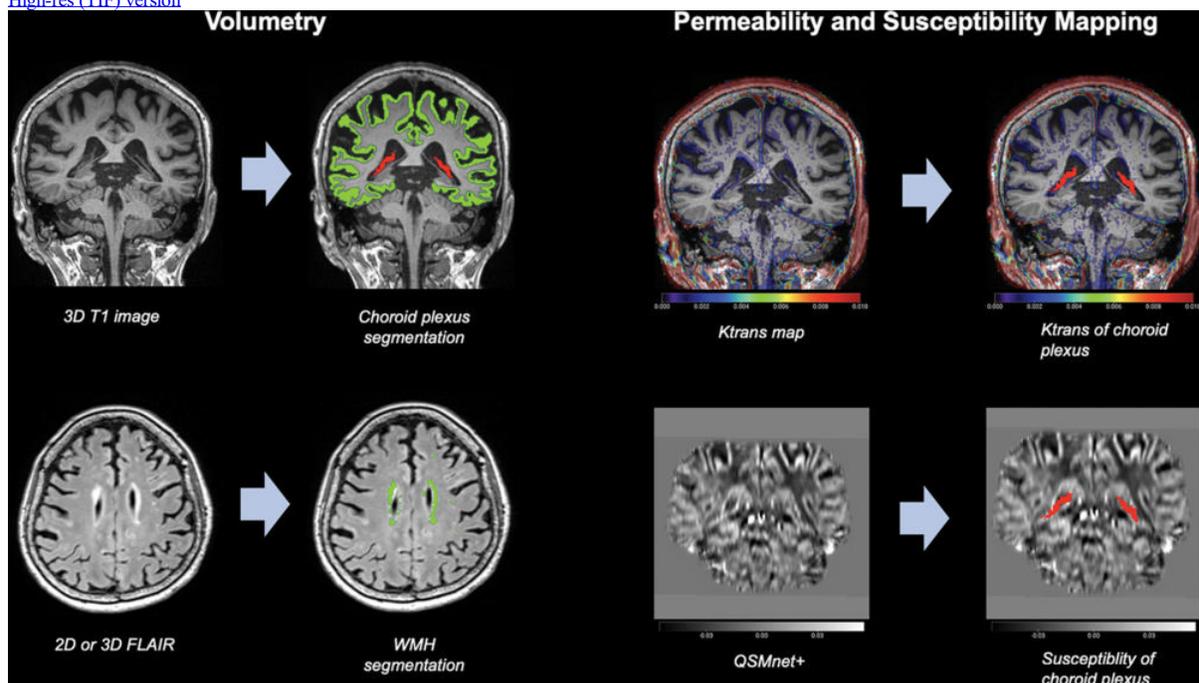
MRI processing steps. For volumetry (left), choroid plexus (CP) volume (red) and cerebral cortex volume (green) are segmented from T1-weighted volumetric images by using an automatic volumetric software (Inbrain) based on the FreeSurfer 6.0 platform (upper row). White matter hyperintensity (WMH) volumes (green) are also segmented from three-dimensional (3D) or two-dimensional (2D) fluid-attenuated inversion-recovery
